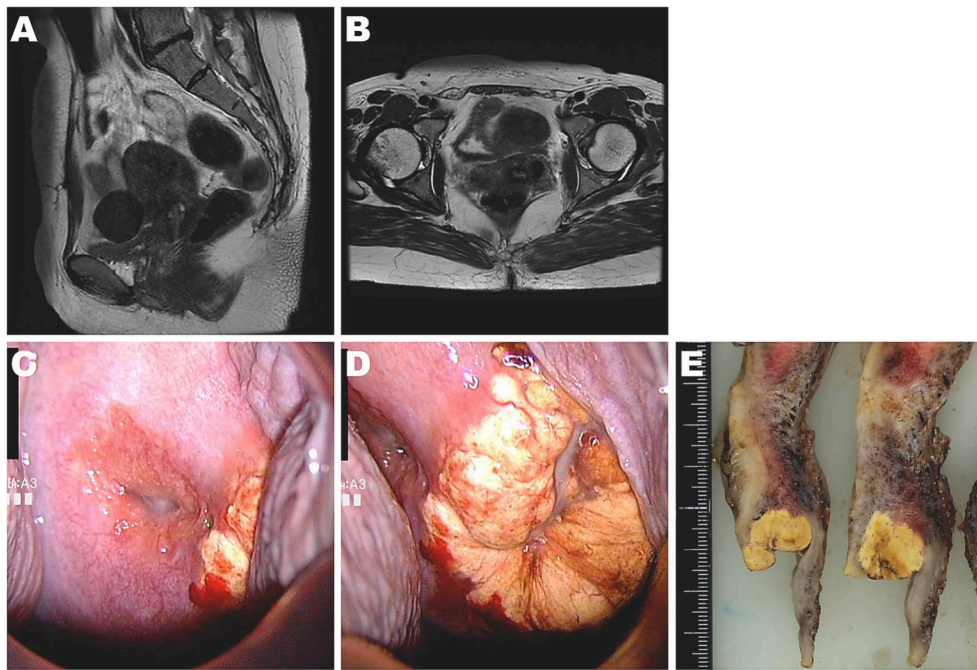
The lesion of the uterine cervix was not detected on MRI after neoadjuvant chemotherapy (A: T2-emphasized sagittal imaging, B: T2-emphasized horizontal imaging). An image of the cervix during colposcopy showed a necrotic tumor on the left of the external os, measuring 3 cm at its greatest dimension (C, D). Sections of the formalin-fixed uterine cervix after surgery (E).
